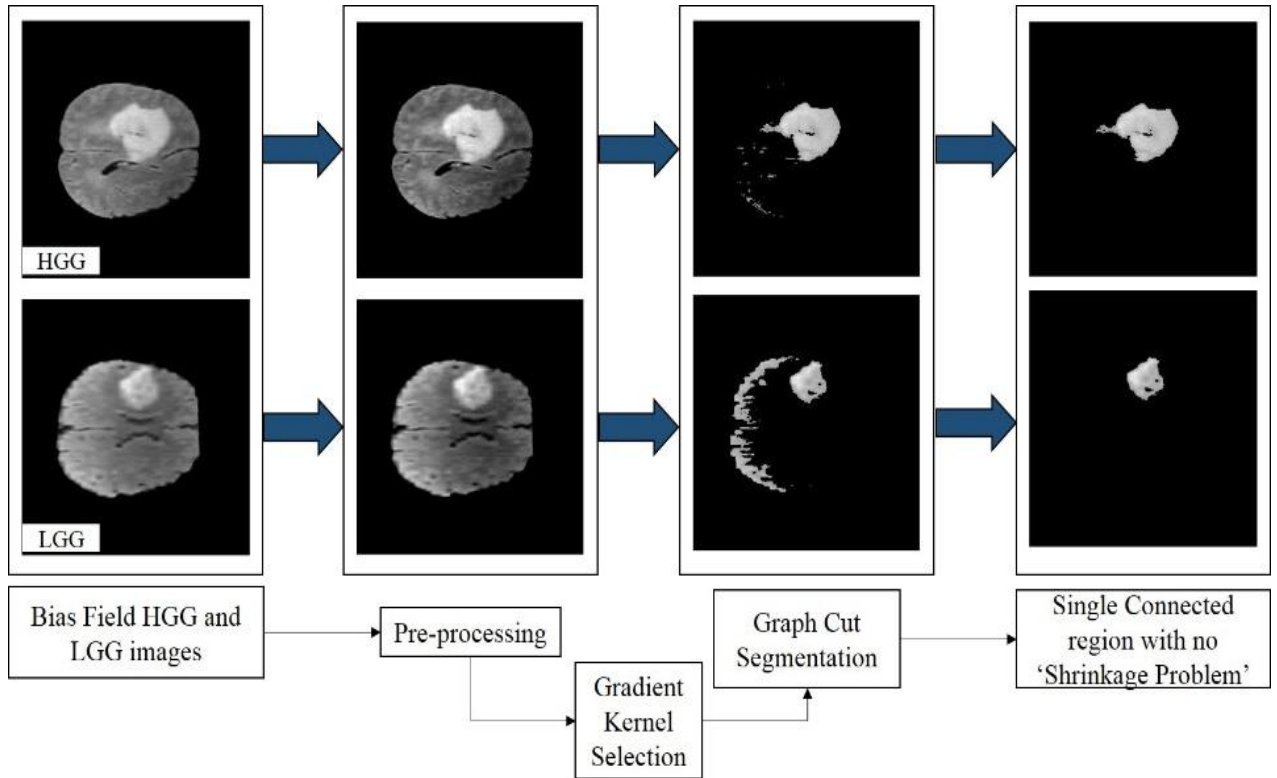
Segmentation of MRI employing GBKS GC method applied on the bias field images
